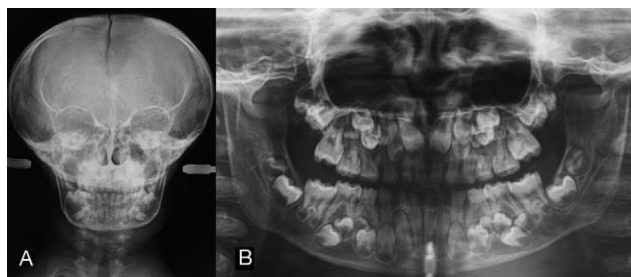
Case 1. (A) Front teloradiography (age 8) showing typical signs of open metopic suture, patent anterior fontanel, inverted pear-shaped calvaria (brachycephaly), invisible paranasal sinuses. (B) First panoramic x-ray showing typical signs of parallel ramus, supernumerary teeth, and nonexfoliated deciduous teeth.
